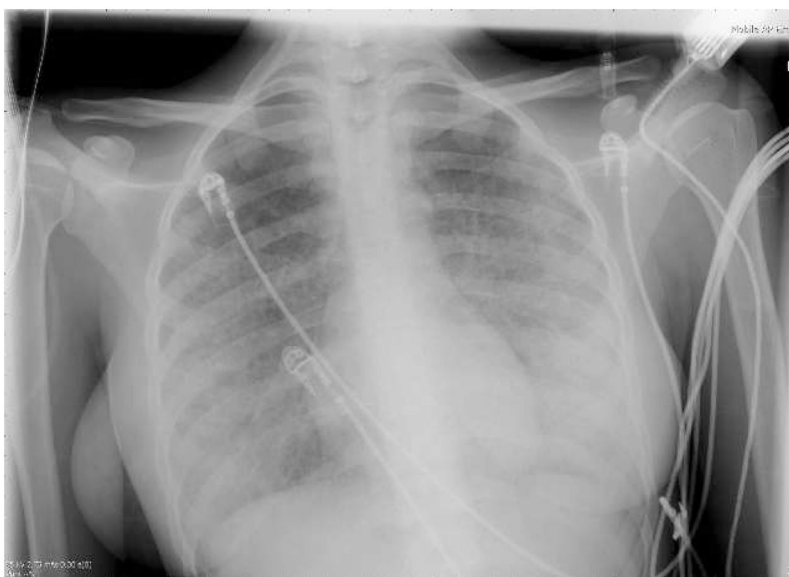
Chest radiograph of a patient with newly-diagnosed HIV infection presenting with severe PCP. There is diffuse bilateral interstitial shadowing, more marked on the left. Courtesy of Robert F. Miller, MBBS CBiol FRSB FRCP; used with permission.
